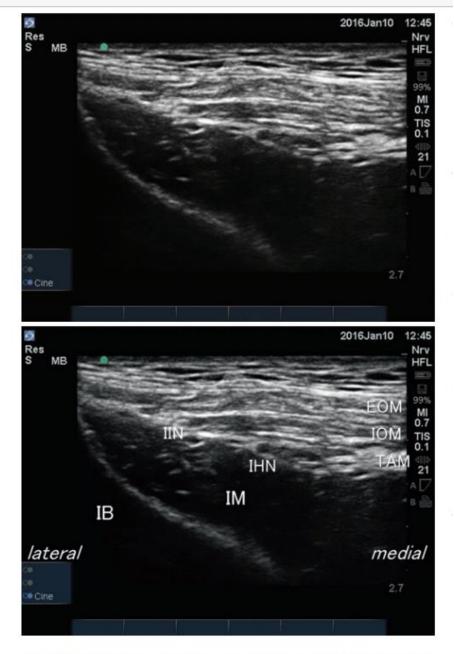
Typical sonographic images for ilioinguinal/iliohypogastric nerve block
